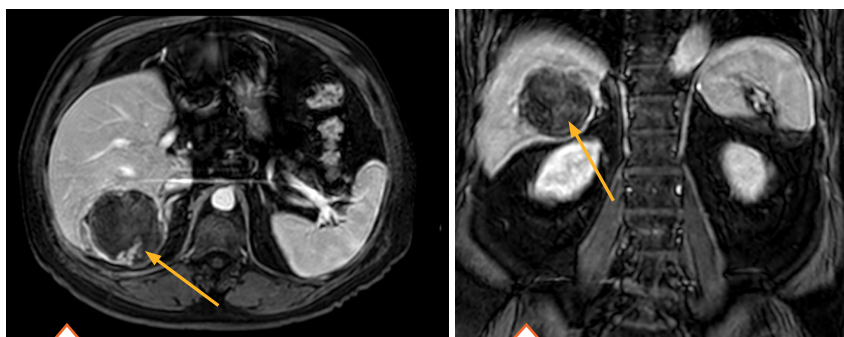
Axial (left) and coronal (right) contrast enhanced MR images obtained 5 weeks after Y90 treatment demonstrate complete imaging response (CR) according to mRECIST criteria. High signal tissue on axial image did not wash out on delayed phase imaging and was deemed low suspicion for residual viable tumor.
